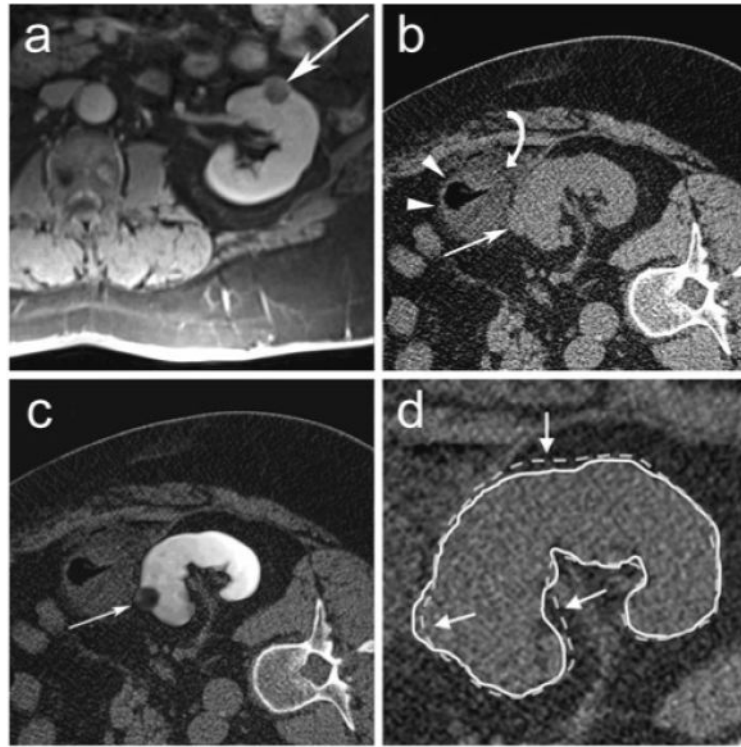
61-year-old male with left renal cell carcinoma. a Pre-procedural transverse contrast-enhanced spoiled gradient echo MR image of patient in supine position in a 1.5T scanner shows a 1.9 cm left renal mass (*arrow*). b Transverse unenhanced planning CT scan in the right lateral decubitus position shows exophytic portion of left renal mass (*arrow*) but the central extent of the tumor is not visible. The mass (*white arrow*) is obscured further by the colon (*white arrowheads*) and injected saline (*curved white arrow*) used to separate the colon from the mass. c MR image fused with CT image after non-rigid registration technique shows full extent of mass in the left kidney (*arrow*). d The renal contour derived from registered MR images using non-rigid registration (*solid white line*) matches the renal contour on the CT image (*white arrows*) better than the renal contour derived from registered MR images using rigid registration (*dotted white line*)
